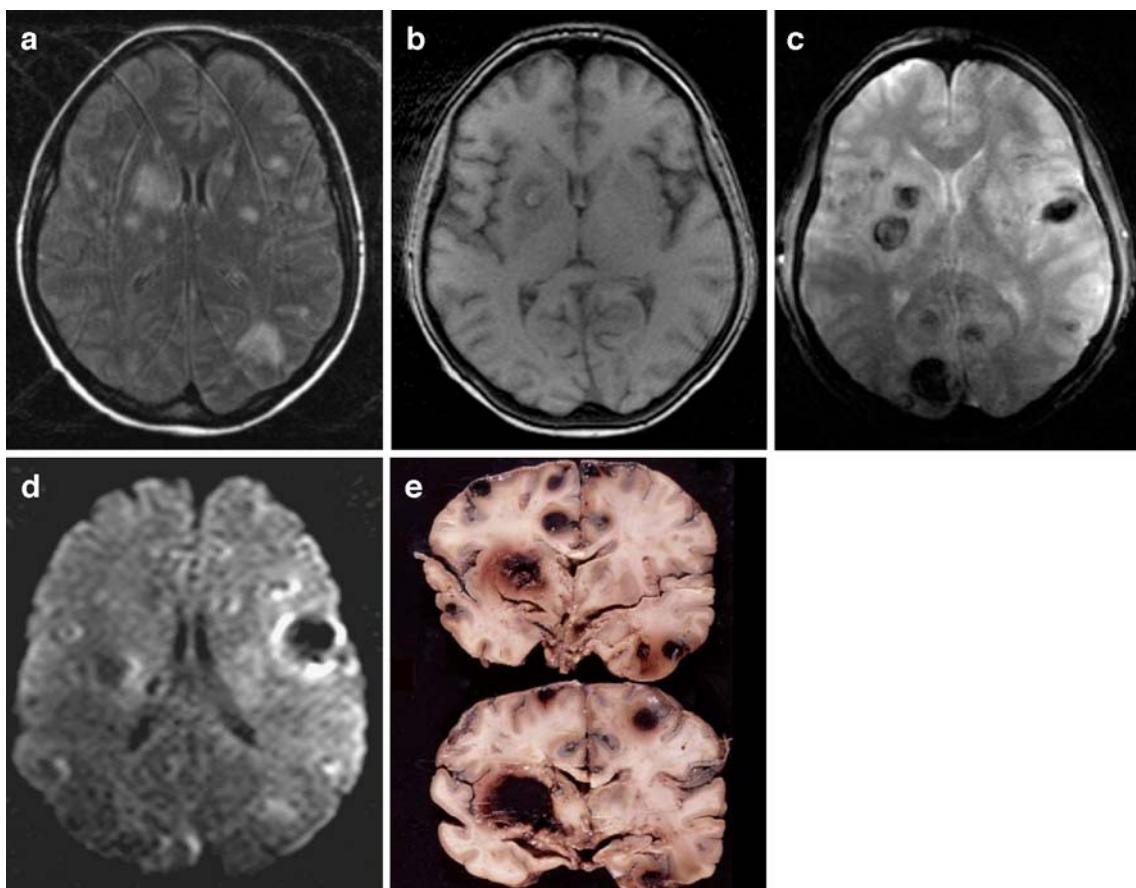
a Axial fluid-attenuated inversion recovery (FLAIR) MR image ($TR/TE/TI=11,000/120/2,800$) shows multiple hyperintense lesions located in subcortical regions bilateral and in the basal ganglia. b On unenhanced axial T1-weighted MR image ($TR/TE/Flip^{\circ}=239/2/90^{\circ}$) the lesion in the right basal ganglia is slightly hyperintense and surrounded by a hypointense rim, suggesting subacute hemorrhage. Most of the lesions seen on the FLAIR-weighted MR image are isointense on T1-weighted MR image. c On gradient-echo MR image ($TR/TE=1,027/23$) the lesions are iso/
